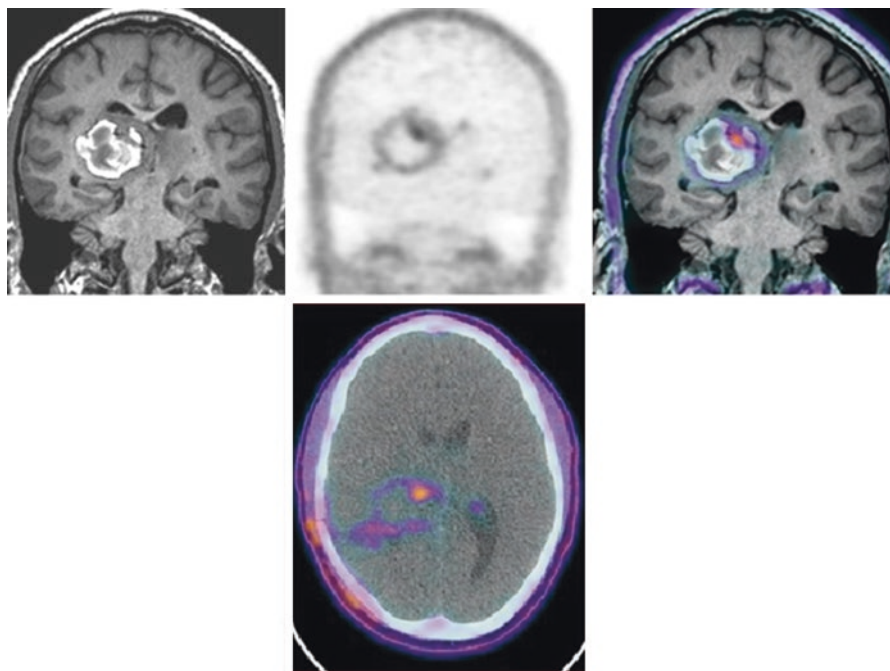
Brain tumor on T1 MRI, ^{18}F choline PET, fused PET/MRI, and PET/CT. Notice the metabolic activity on ^{18}F choline which indicates the most aggressive part of the tumor. The high signal on T1 is because of the hemorrhage after biopsy
